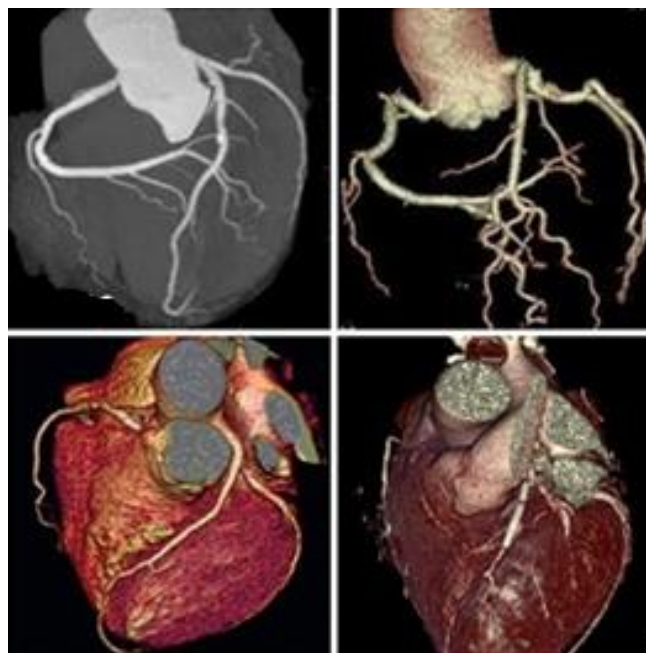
The reconstructed image of the heart based on CT images
